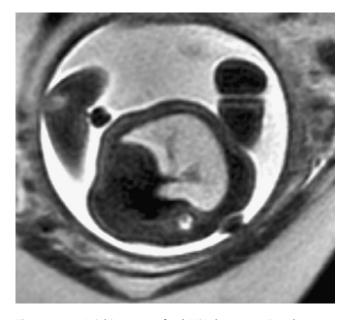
Axial image on fetal MRI demonstrating the compensatorily enlarged single lung with shift of mediastinum away from the lung toward the side of the agensis.
